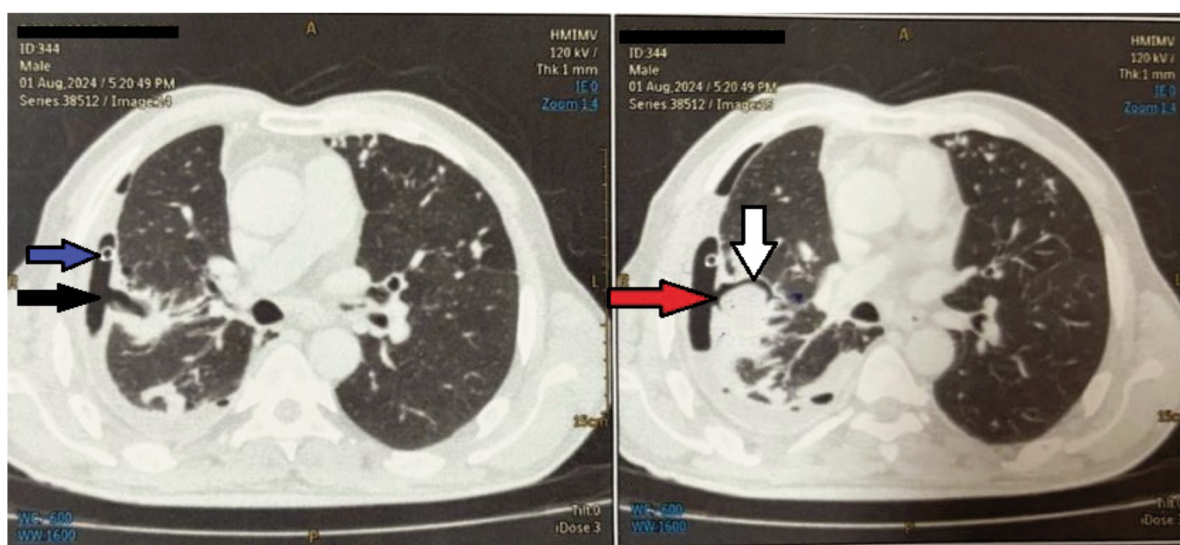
Chest Computed Tomography (CT) scan showing a right pulmonary cavity containing a rounded mass, consistent with an aspergilloma (white arrow), and a bronchopleural fistula identified by an interruption of the visceral pleura (red arrow), as well as the pneumothorax (black arrow) with a chest tube in place (blue arrow).
